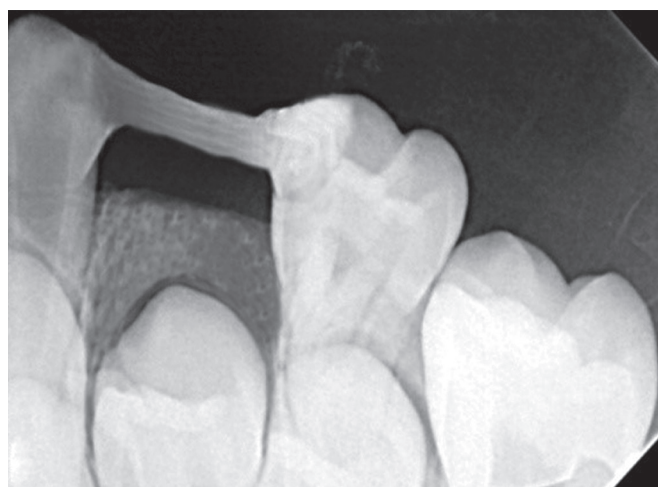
Radiographic image of GFRC space maintainer at follow-up
